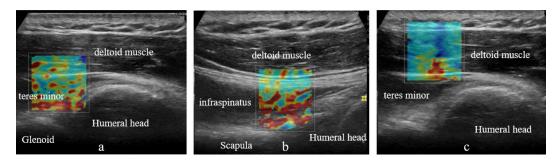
Ultrasound image of teres minor, infraspinatus muscle, and deltoid muscle. a: teres minor, b: infraspinatus, c: deltoid muscle.
